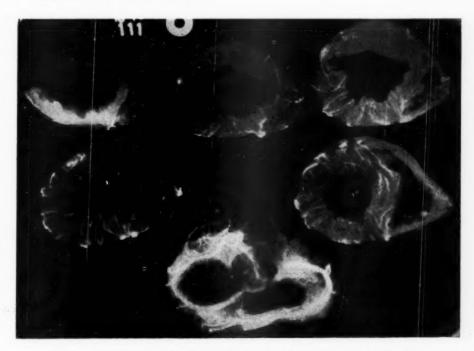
Roentgenogram of the injected heart in Case 79 with large anterolateral and septal infarct, demarcated by its avascularity.
